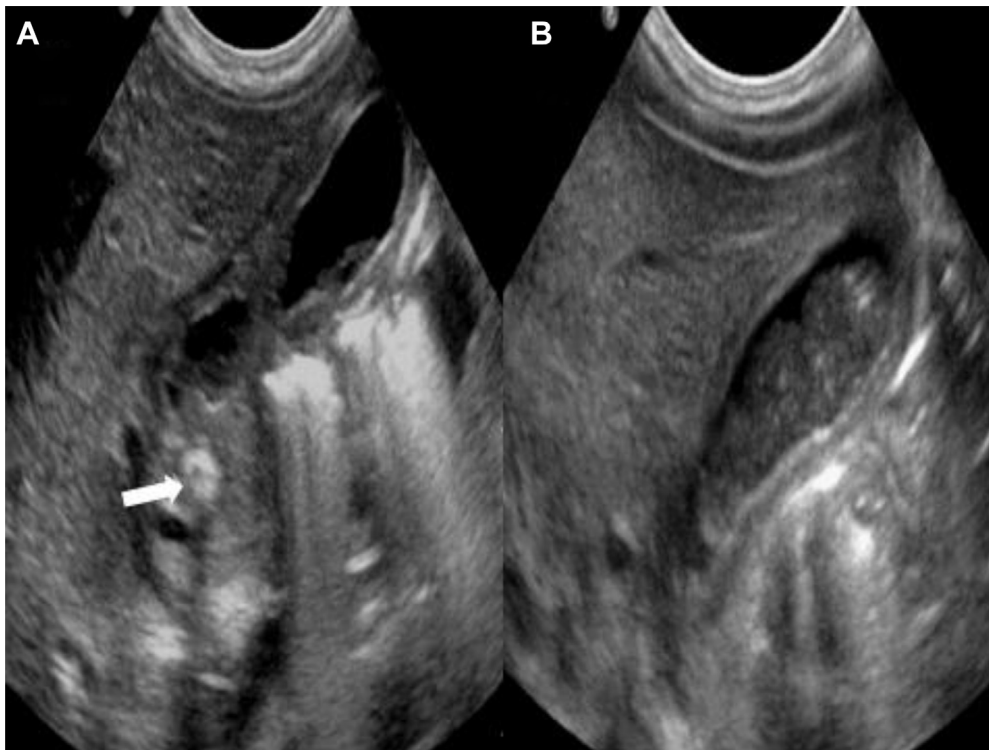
(A) Abdominal ultrasound denoting the longitudinal view of the gallbladder with a visualized calculus in the cystic duct (white arrow). (B) Longitudinal view of the gallbladder showing sludge within the lumen.
